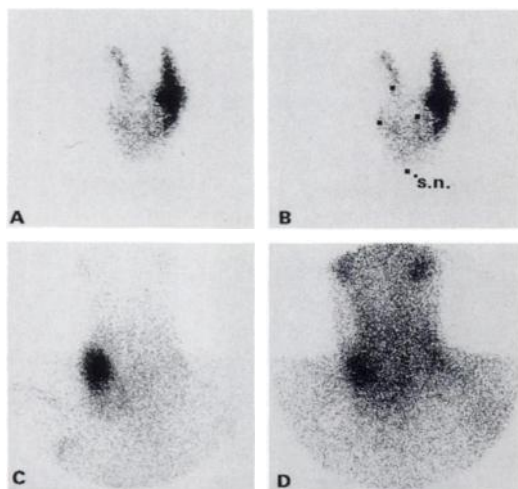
Technetium-99m and ^{201}Tl thyroid scintigraphy in a 54-yr-old female. A cold nodule of the right lower lobe (A,B, s.n.-sternal notch) is visualized on the $^{99\text{m}}\text{Tc}$ image. An increased ^{201}Tl uptake is demonstrated in the early (15 min, C) and the late (3 hr, D) images with a visual score of +2 and +2, and a L/N of 3.68 and 1.58, respectively. The diagnosis was papillary carcinoma.
